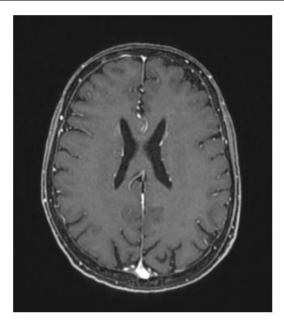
MRI post-RT (36 months after RT)
